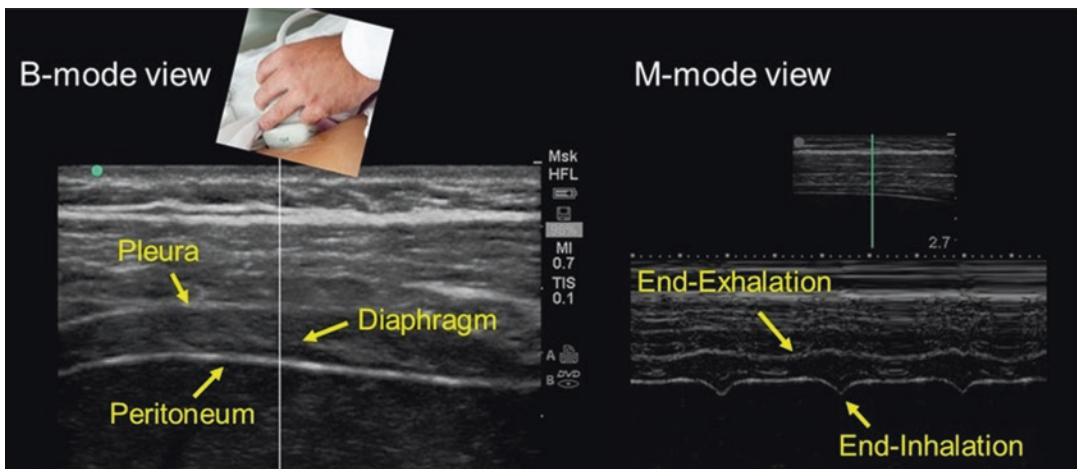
Ultrasound image of the zone of apposition of the diaphragm. In bright-mode (B-mode; *left panel*), the diaphragm appears as a three-layer structure. In motion-mode (M-mode; *right panel*), the diaphragm is thinnest at end-exhalation and thickest at end-inhalation;
